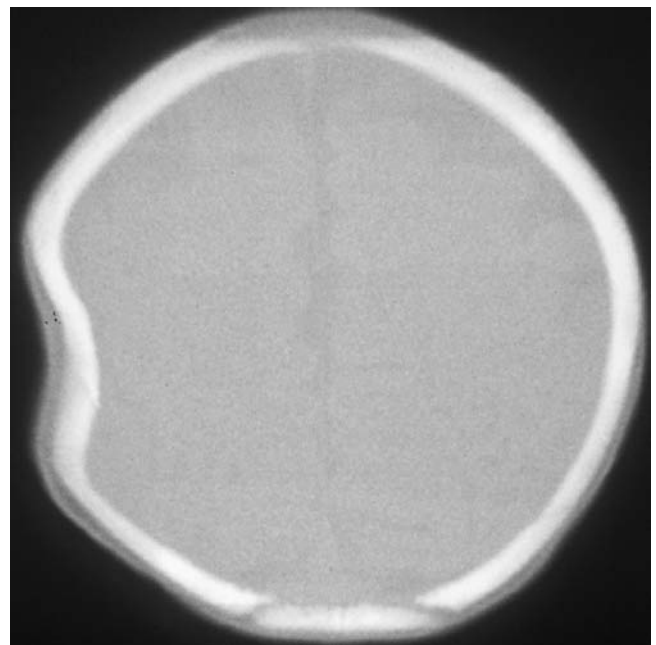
Depressed skull fracture. This 3-month-old boy fell out of bed and was noted to have a palpable depression of the skull. Head computed tomographic imaging shows a "ping pong ball"-type depressed skull fracture. No intracranial abnormalities were identified.
